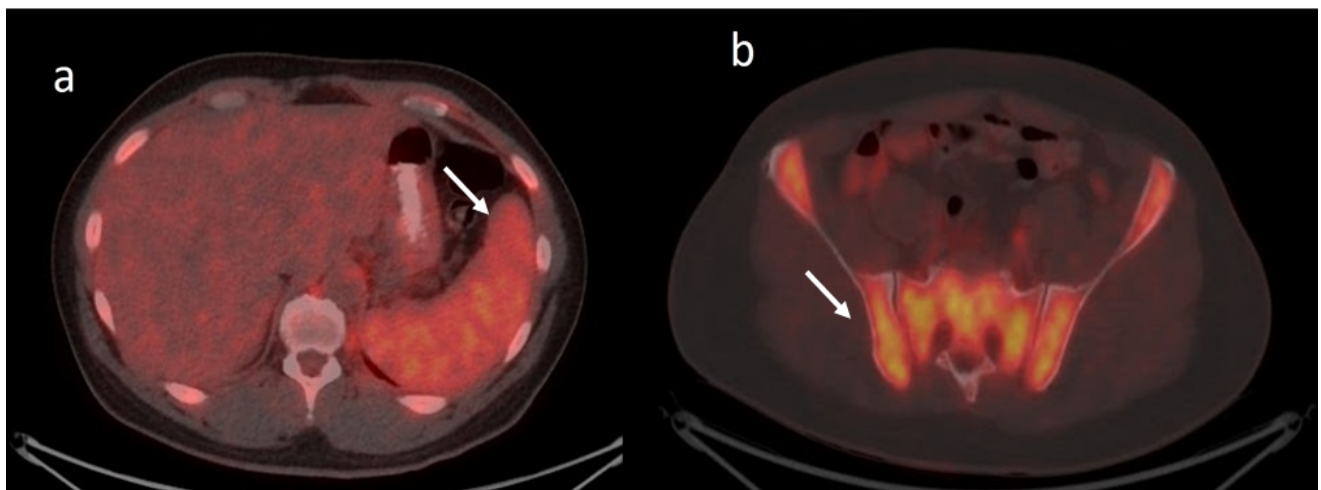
Fused ^{18}F -FDG PET/CT images showing diffusely increased ^{18}F -FDG uptake in spleen (a) and bone marrow (b) (white arrows).
